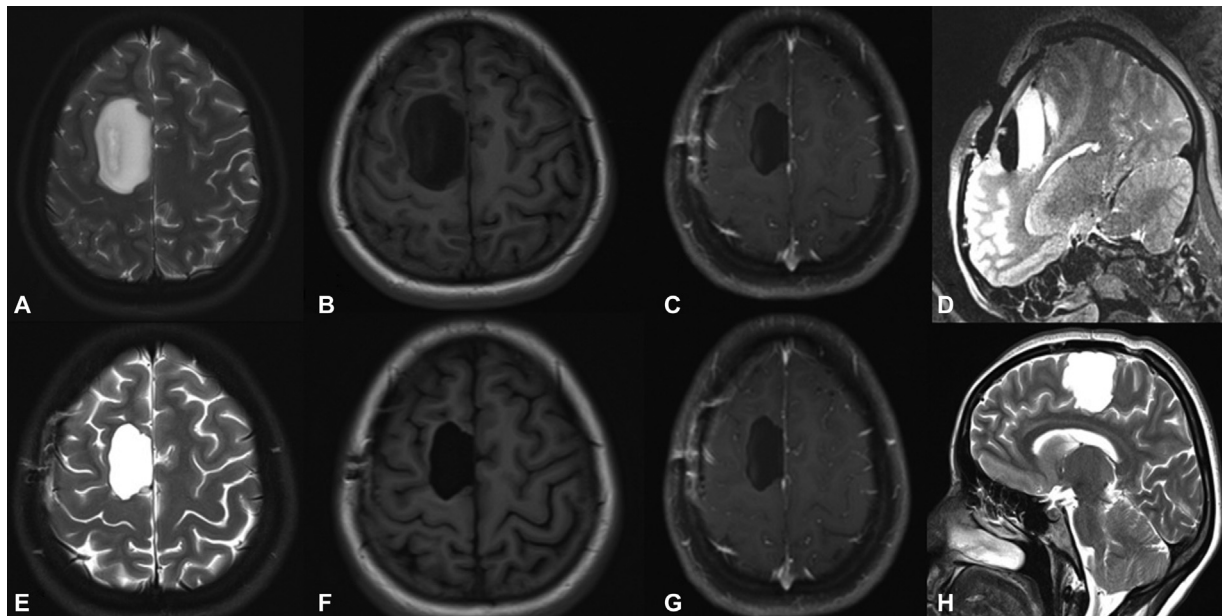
Preoperative and postoperative MRI images of case 1. (A–C) are the preoperative images of T2 axial, T1 axial, and T1 postcontrast axial images, respectively, showing T2-hyperintense, T1-hypointense, and nonenhancing lesion in right posterior superior frontal gyrus and involving supplementary motor area (SMA) region. (D) is the intraoperative T2 sagittal image showing total excision of the tumor. (E–H) are the 3 months postoperative images of T2 axial, T1 axial plain, T1 axial postcontrast, and T2 sagittal images, respectively, showing no residual/recurrence of tumor.
